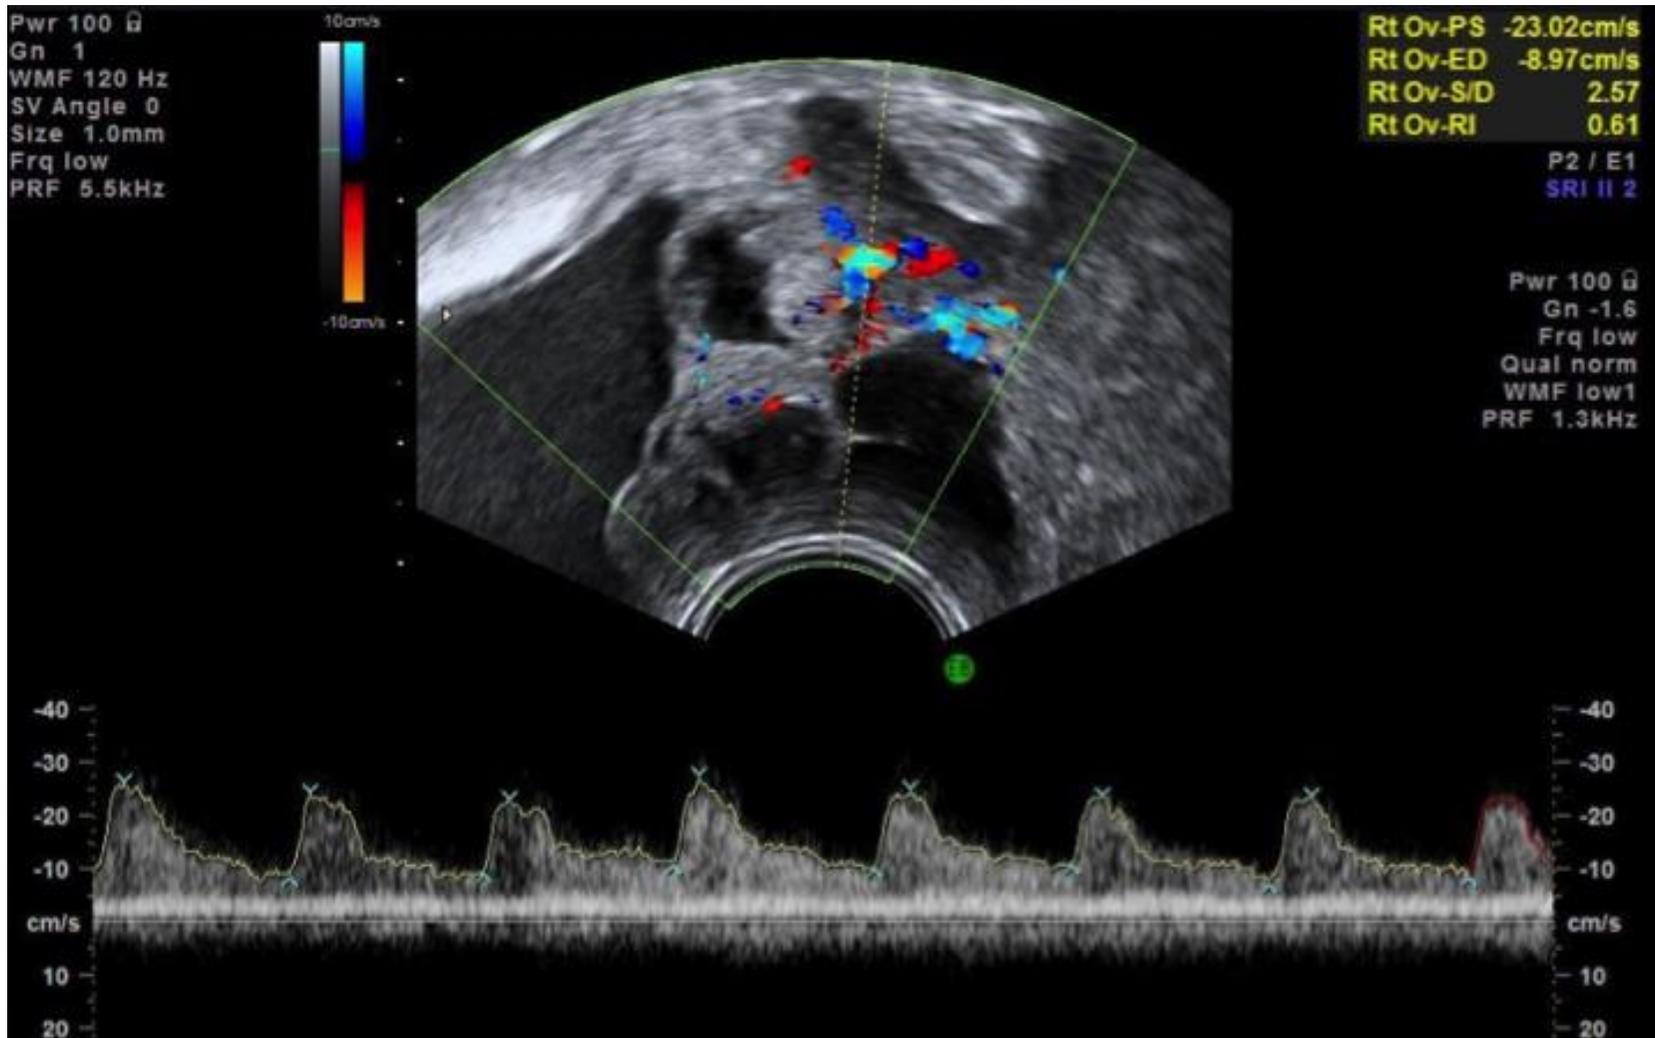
B-mode ultrasound image with Doppler velocimetry of a blood vessel within a malignant ovary
